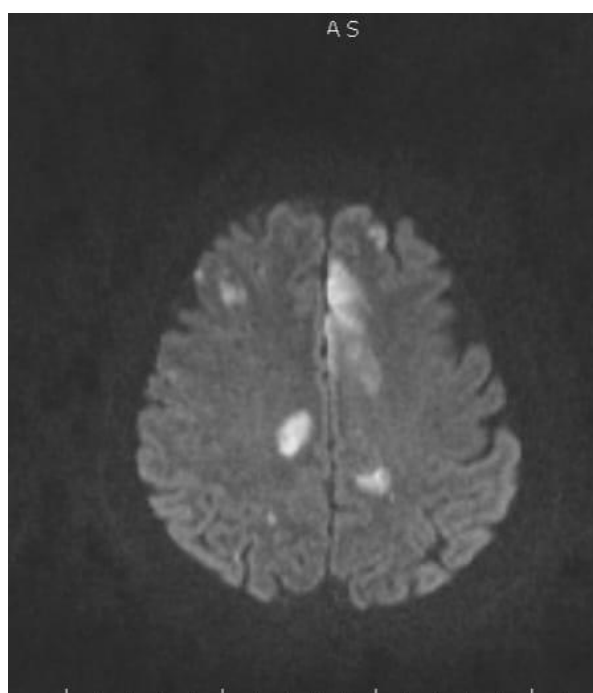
Regions of intracerebral occlusion on MR image sections-parietal and frontal lobes
